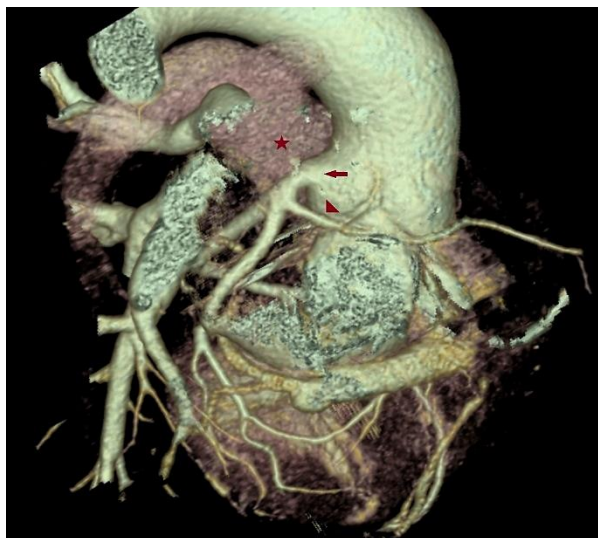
Multidetector computed tomography (MDCT) with volume rendered reconstruction (VR) showing trifurcation of left main artery into coronary angiography showing trifurcation of left main artery into left anterior descending (LAD), left circumflex (LCX), and right coronary artery (RCA) (red arrow: RCA; asterisk: Pulmonary trunk)
